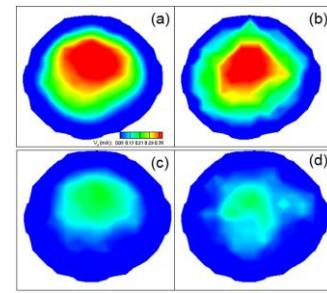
Velocity contours of PSCH (a, c) vs. MRI (b, d) at systole (a, b) and diastole (c, d)
